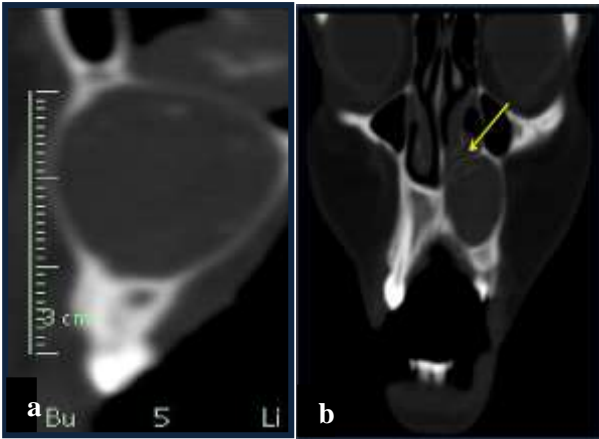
(a) Ortho-radial section showing thinning of buccal and palatal cortex of maxilla; (b) Coronal CT section showing upward displacement of nasal floor by lesion (arrow).
